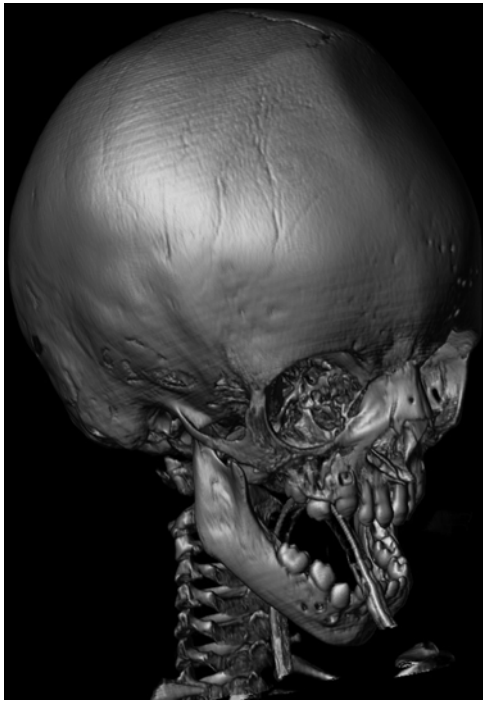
Patient with Crouzon syndrome with premature fusion of the cranial sutures. Three-dimensional reconstructed image from CT images shows ridge in the midline of the frontal bone which results from early fusion of the metopic suture
